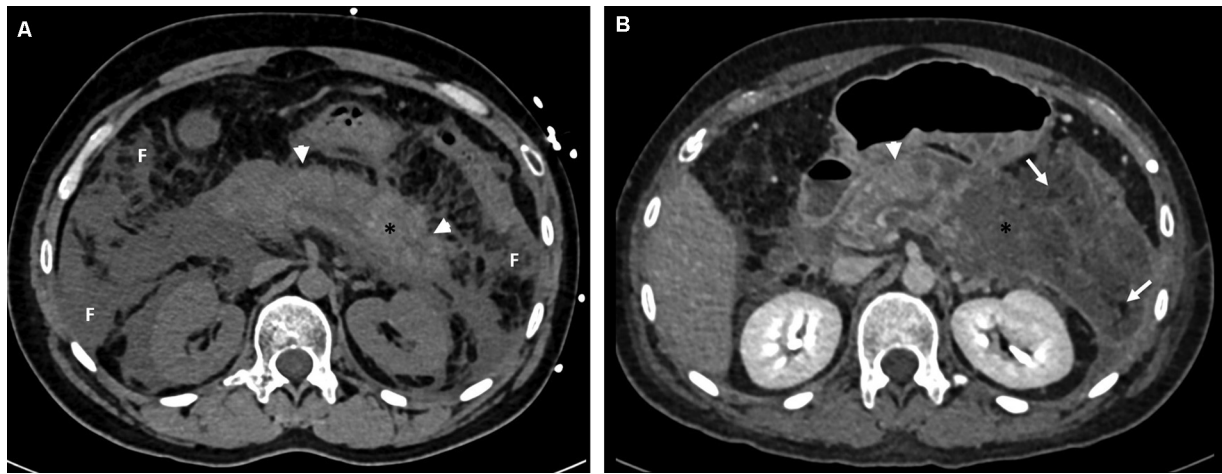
Computed tomography (CT) in a 32 /M with acute alcohol-related necrotizing pancreatitis with extrapancreatic fat necrosis with history of alcohol abuse. (A) Noncontrast-enhanced CT (NECT) in axial plane shows a bulky pancreas [white arrowhead] and raised density in the distal body (black star). (B) Contrast-enhanced CT (CECT) at the same levels after a week shows necrosis in the distal body (black star), corresponding to A. Peripancreatic fluid in relation to the distal body has increased and now shows fat necrosis (white arrow). White arrowhead shows normal enhancement in the proximal body of pancreas.
